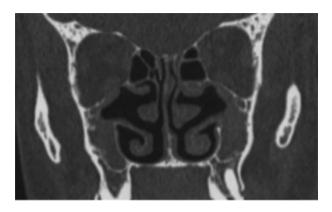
Coronal computed tomography scan of patient three, demonstrating complete opacification of both maxillary antra and lateralised posterior maxillary fontanelles.
